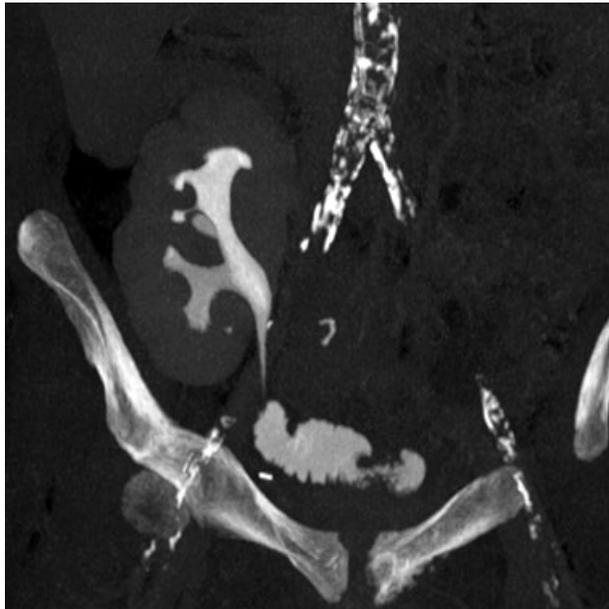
CT-urography of patient 4, who had previously undergone renal transplantation to the right iliac vessels and subsequent radical cystectomy with Studer orthotopic neobladder, revealing normal appearance of the pyelocalyceal system, a short ureter and opacification of the afferent nondetubularised ileal loop.
